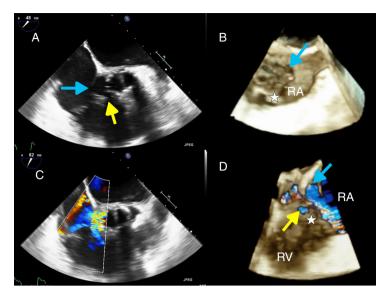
Transesophageal echocardiography in mid-esophageal view: (A) two-dimensional transesophageal echocardiography (2D-TEE) showing a cavity between the aortic prosthesis and the right atrium RA corresponding to a PA, which communicates with the RA (blue arrow) and with the RV through the base of the TSL (yellow arrow); (B) three-dimensional transesophageal echocardiography (3D-TEE), showing the PA from the RA in the middle of the image, the aortic prosthesis on the left, the superior vena cava on the right, the interatrial septum at the top and the TSL at the bottom; (C) 2D-TEE showing turbulent flow from the PA to the RA and to the RV; (D) 3D-TEE image showing the same defects in more detail. PA: pseudoaneurysm; RA: right atrium; RV: right ventricle; TSL: tricuspid septal leaflet.
